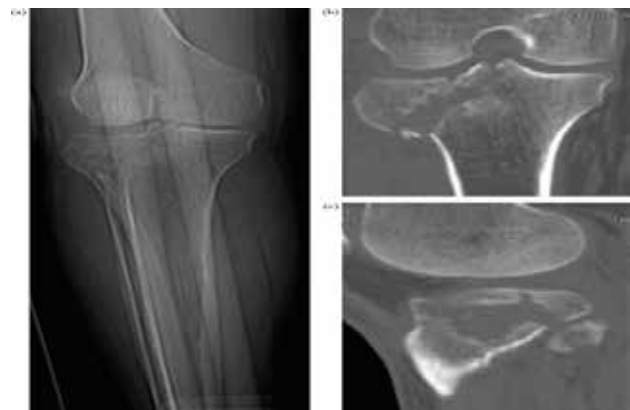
(a) A high-energy bicondylar fracture of the right tibial plateau anteroposterior radiograph coronal (b) and sagittal (c) CT-scan reconstruction graphics.
